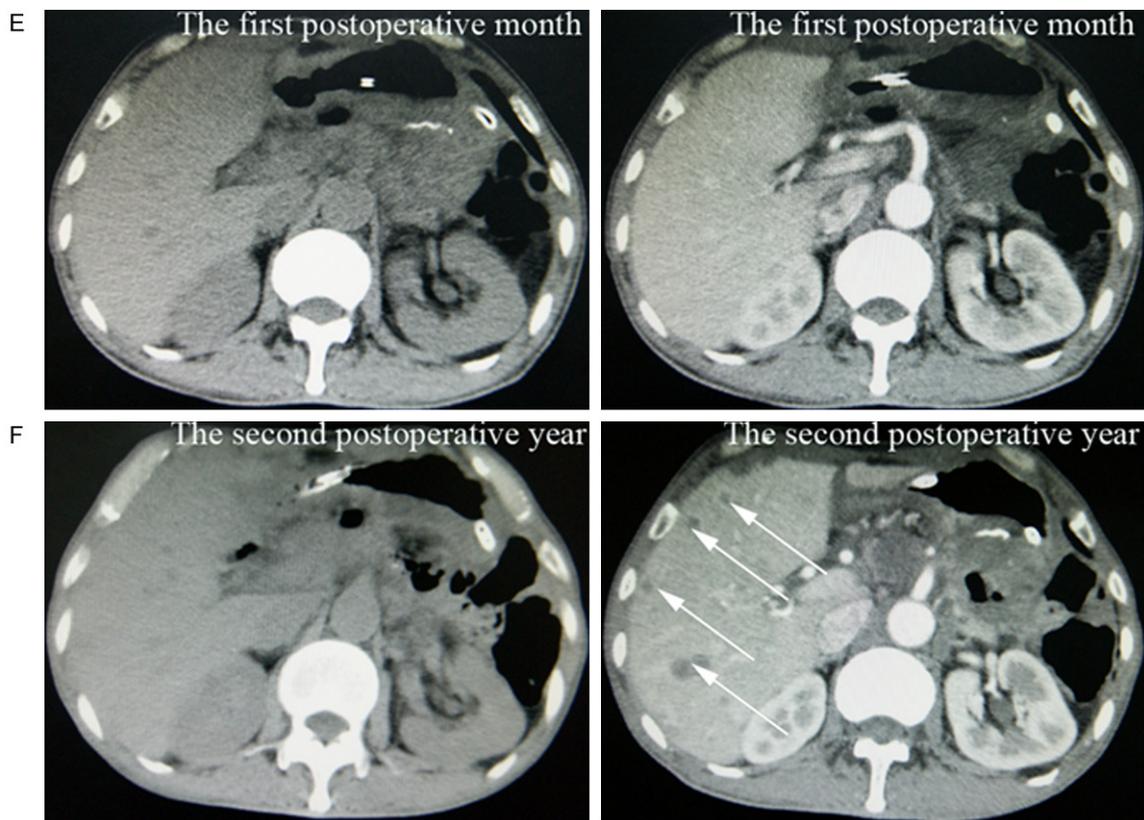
Abdominal CT of the PC patients in preoperative and postoperative phases, respectively. (A) In pre-operation, Plain and contrast enhanced CT of PC in the head of pancreas as arrows suggested. No liver metastasis was found. (B) Plain and contrast enhanced CT of the same PC patient in another CT slice, no liver metastasis was found. (C) Plain and contrast enhanced CT of the same PC patient underwent pancreaticoduodenectomy in the first postoperative year. Several liver metastases were found as arrows suggested. (D) Plain and contrast enhanced CT of the same postoperative patient in another CT slice, several liver metastases were found as arrows suggested. (E) Plain and contrast enhanced CT of another PC patient underwent distal pancreatectomy and splenectomy in the first postoperative month, no liver metastasis was found. (F) Plain and contrast enhanced CT of the same postoperative PC patient in the second postoperative year. Several liver metastases were found as arrows suggested.
